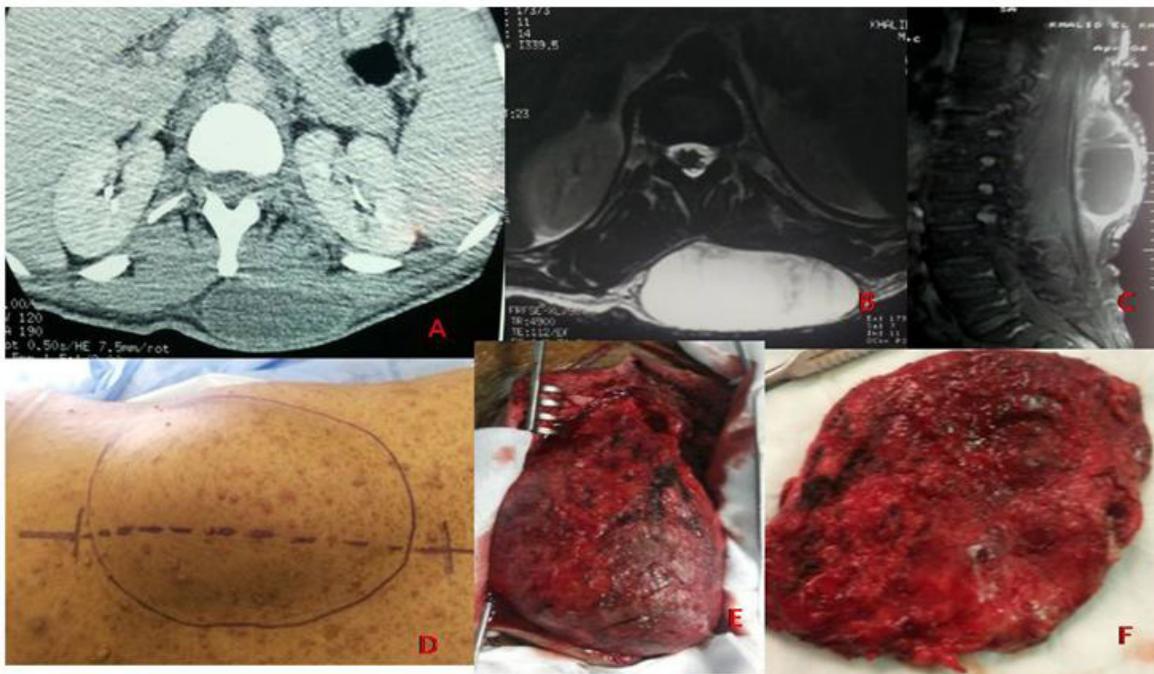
Axial computed tomography (CT) scan (A), axial (B) and sagittal (C) view (MRI) of the lumbar spine showing a voluminous paravertebral mass. (D, E, F) pre and perioperative views showing a large Subcutaneous Paravertebral cyst
